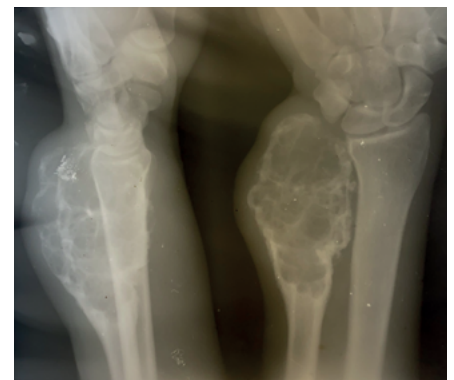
The X-ray of the right wrist
